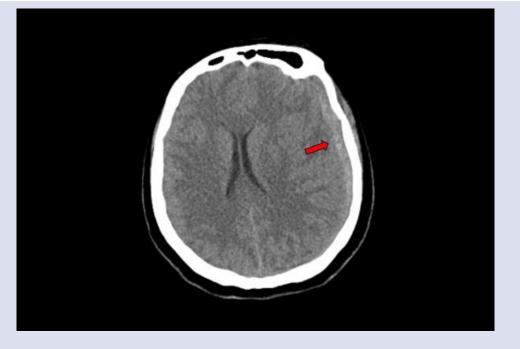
Brain CT image of the patient (A subdural hematoma is marked with a red arrow.)
